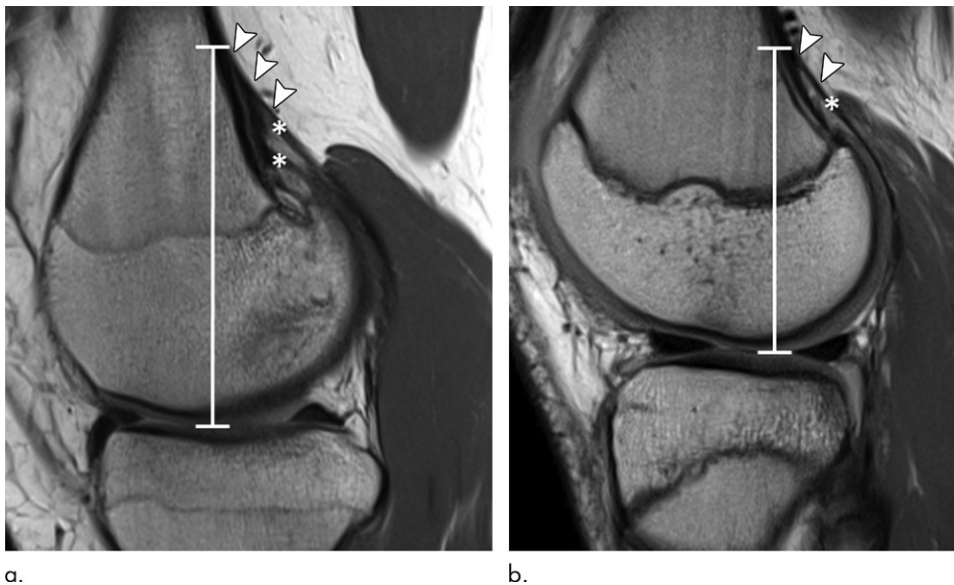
Sagittal proton density-weighted MRI scans in two 15-year-old female control participants without a distal femoral cortical irregularity demonstrate measurement of the tendon attachment position. Images show the craniocaudal position (white line) of the tendon attachment, which is defined as the distance from the level of the joint space to the most cranial attachment of tendon slips (arrowheads) for the (a) medial and (b) lateral head of the gastrocnemius muscle (*). Note that the tendon of the medial gastrocnemius head in a shows two prominent tendon slips.
